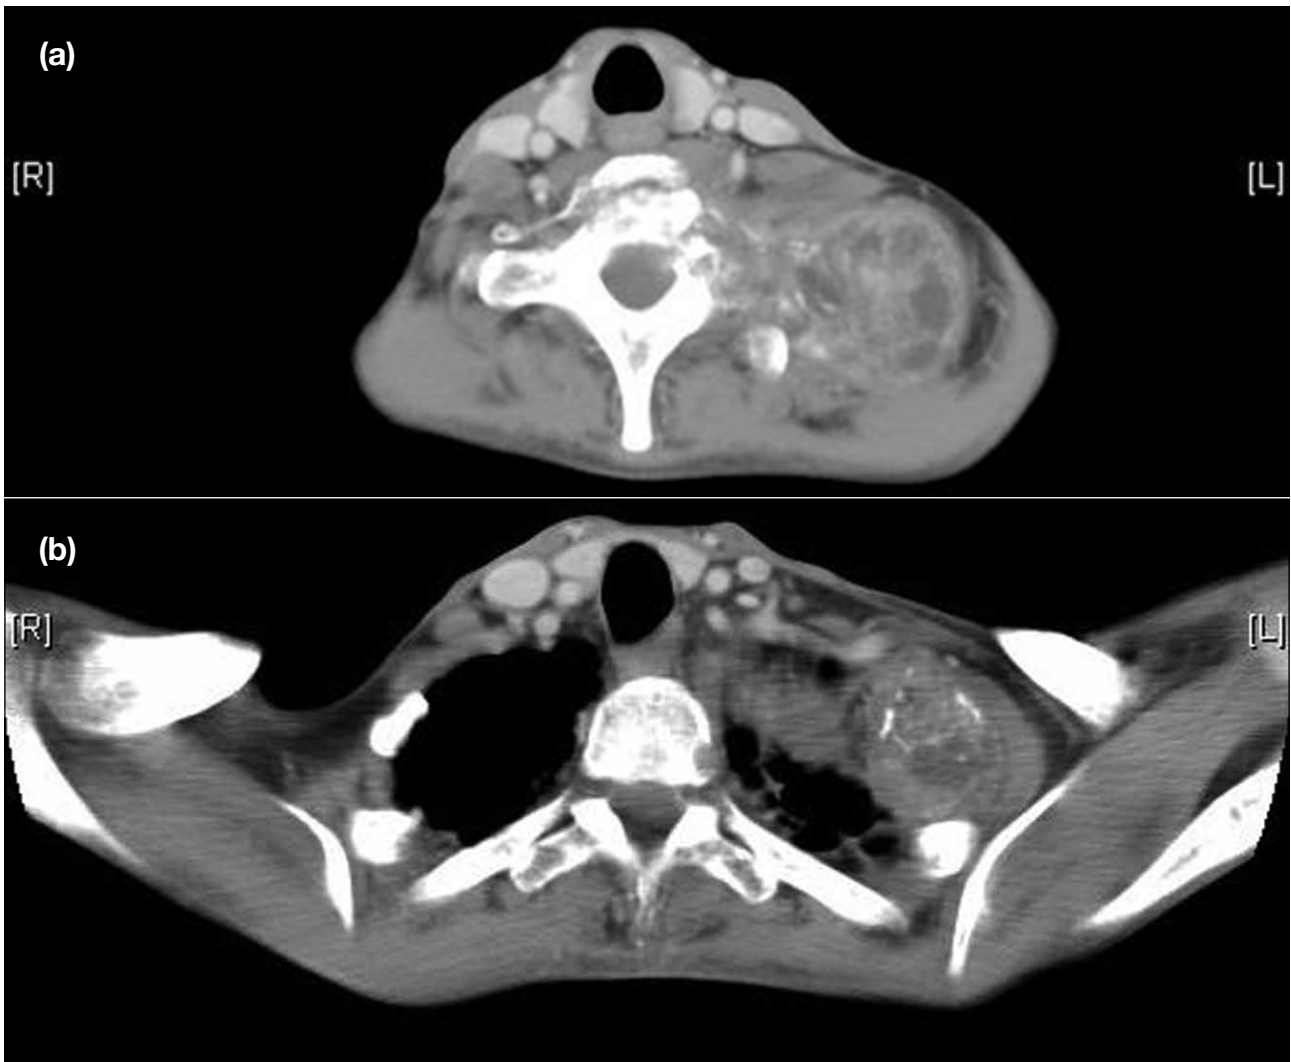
Contrast-enhanced computed tomograms of the patient in June 2009, showing a large left apical chest wall mass invading adjacent vertebra with extension into (a) spinal canal and (b) ribs.
